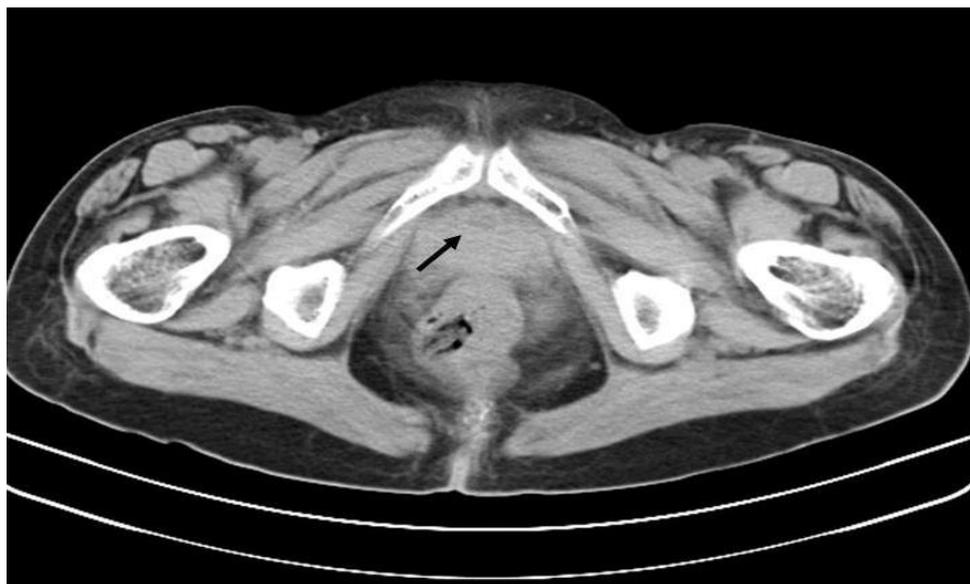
Edematous appearance of urethra in the computed tomogram
